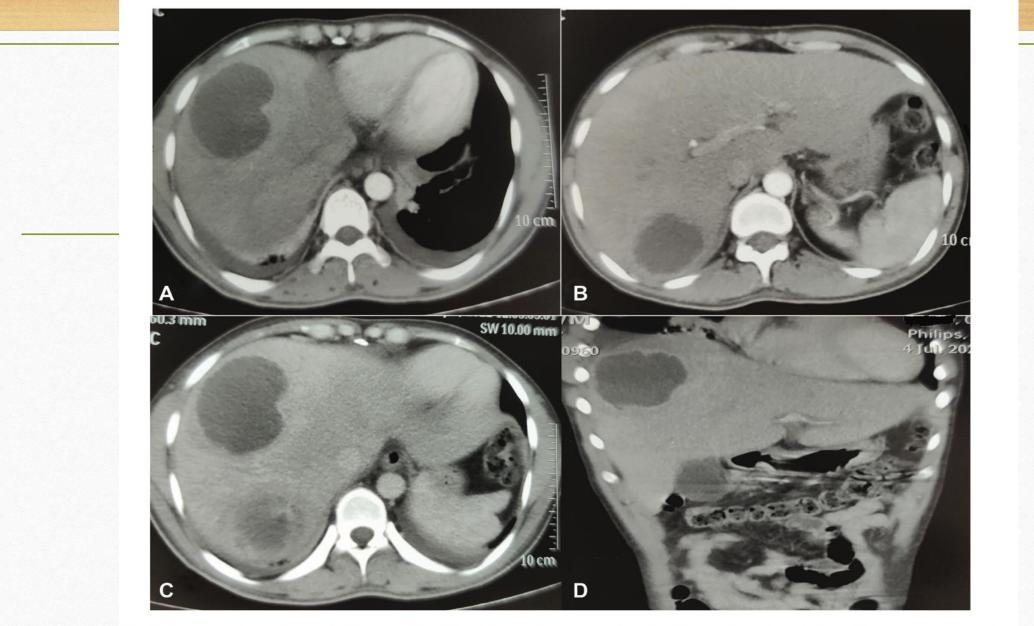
Contrast-enhanced computed tomography of the abdomen showing peripherally enhancing hypodense lesions with shaggy margins and perilesional edema in the right lobe of the liver in the subcapsular region (A, C, D) suggestive of a liver abscess (B).
